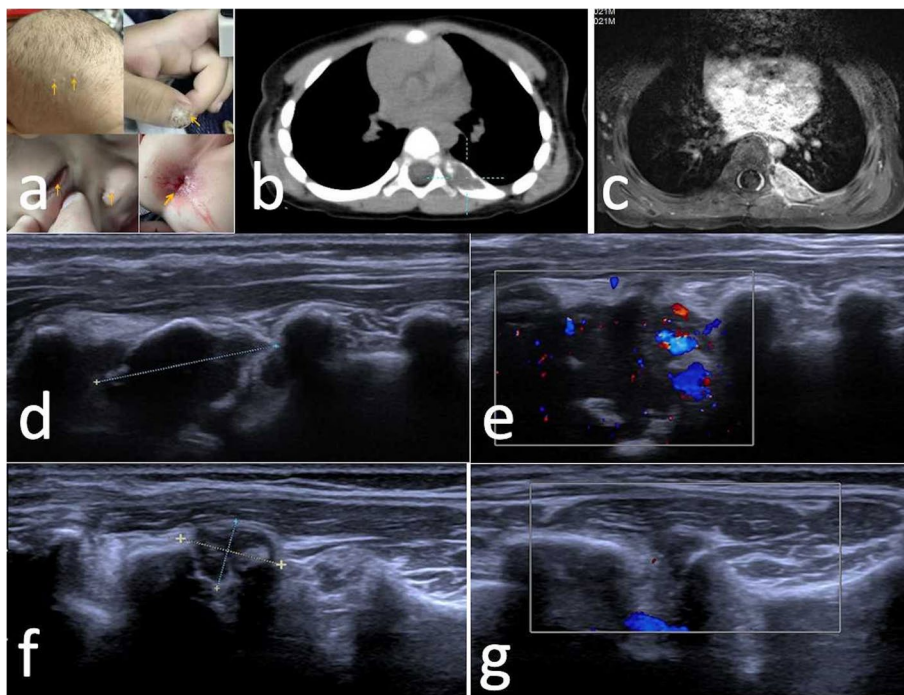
Imaging in a child with MS-LCH. a Physical signs of scalp, nails, eyelids, and anus. b CT shows bone destruction with soft tissue density shadows inside and its CT value was 34Hu. c MR T1W1 enhanced scan showing a mass in the left seventh posterior rib, with significant enhancement and poorly displayed local rib bone. d-e Sonogram showing a left posterior seventh rib lesion with rich blood flow signal. f-g A review four months after first-line chemotherapy showed a markedly reduced lesion and blood flow signal on the sonogram
